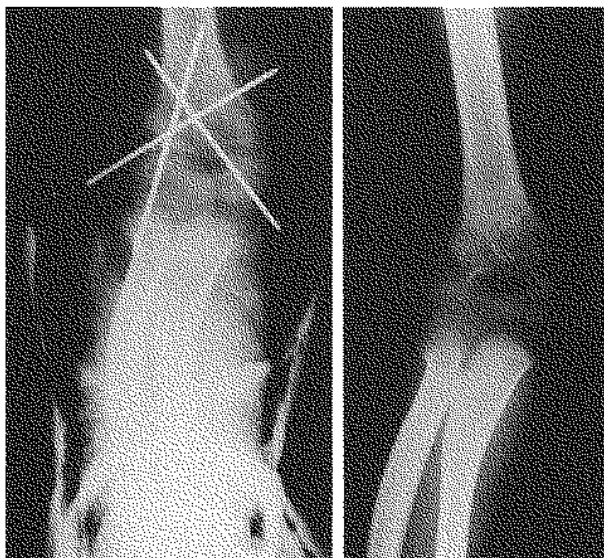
Radiographs of a 4.5-year-old girl (case 2) with a left supracondylar elbow fracture Type III b (a) (b). Note collapse of the lateral column. Two months later the girl was seen in our hospital. There was a valgus angulation of 10 degrees as compared with the normal right side (c) (d).
